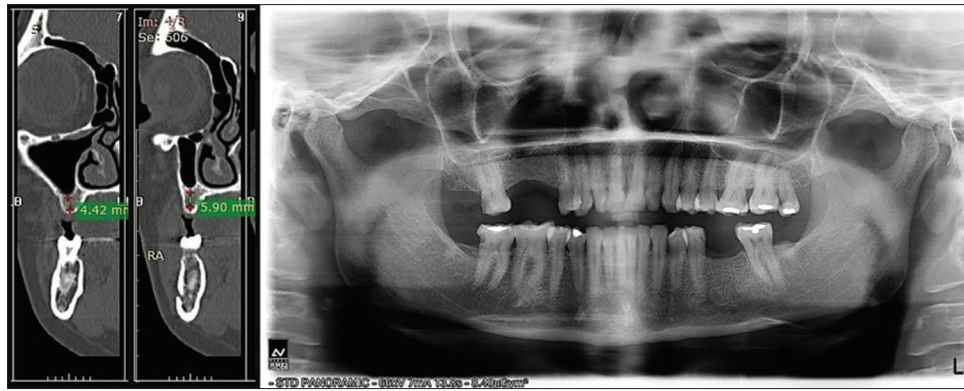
Pre-operative OPG and 0.6-mm paraxial CT sections in relation to 16 and 15
